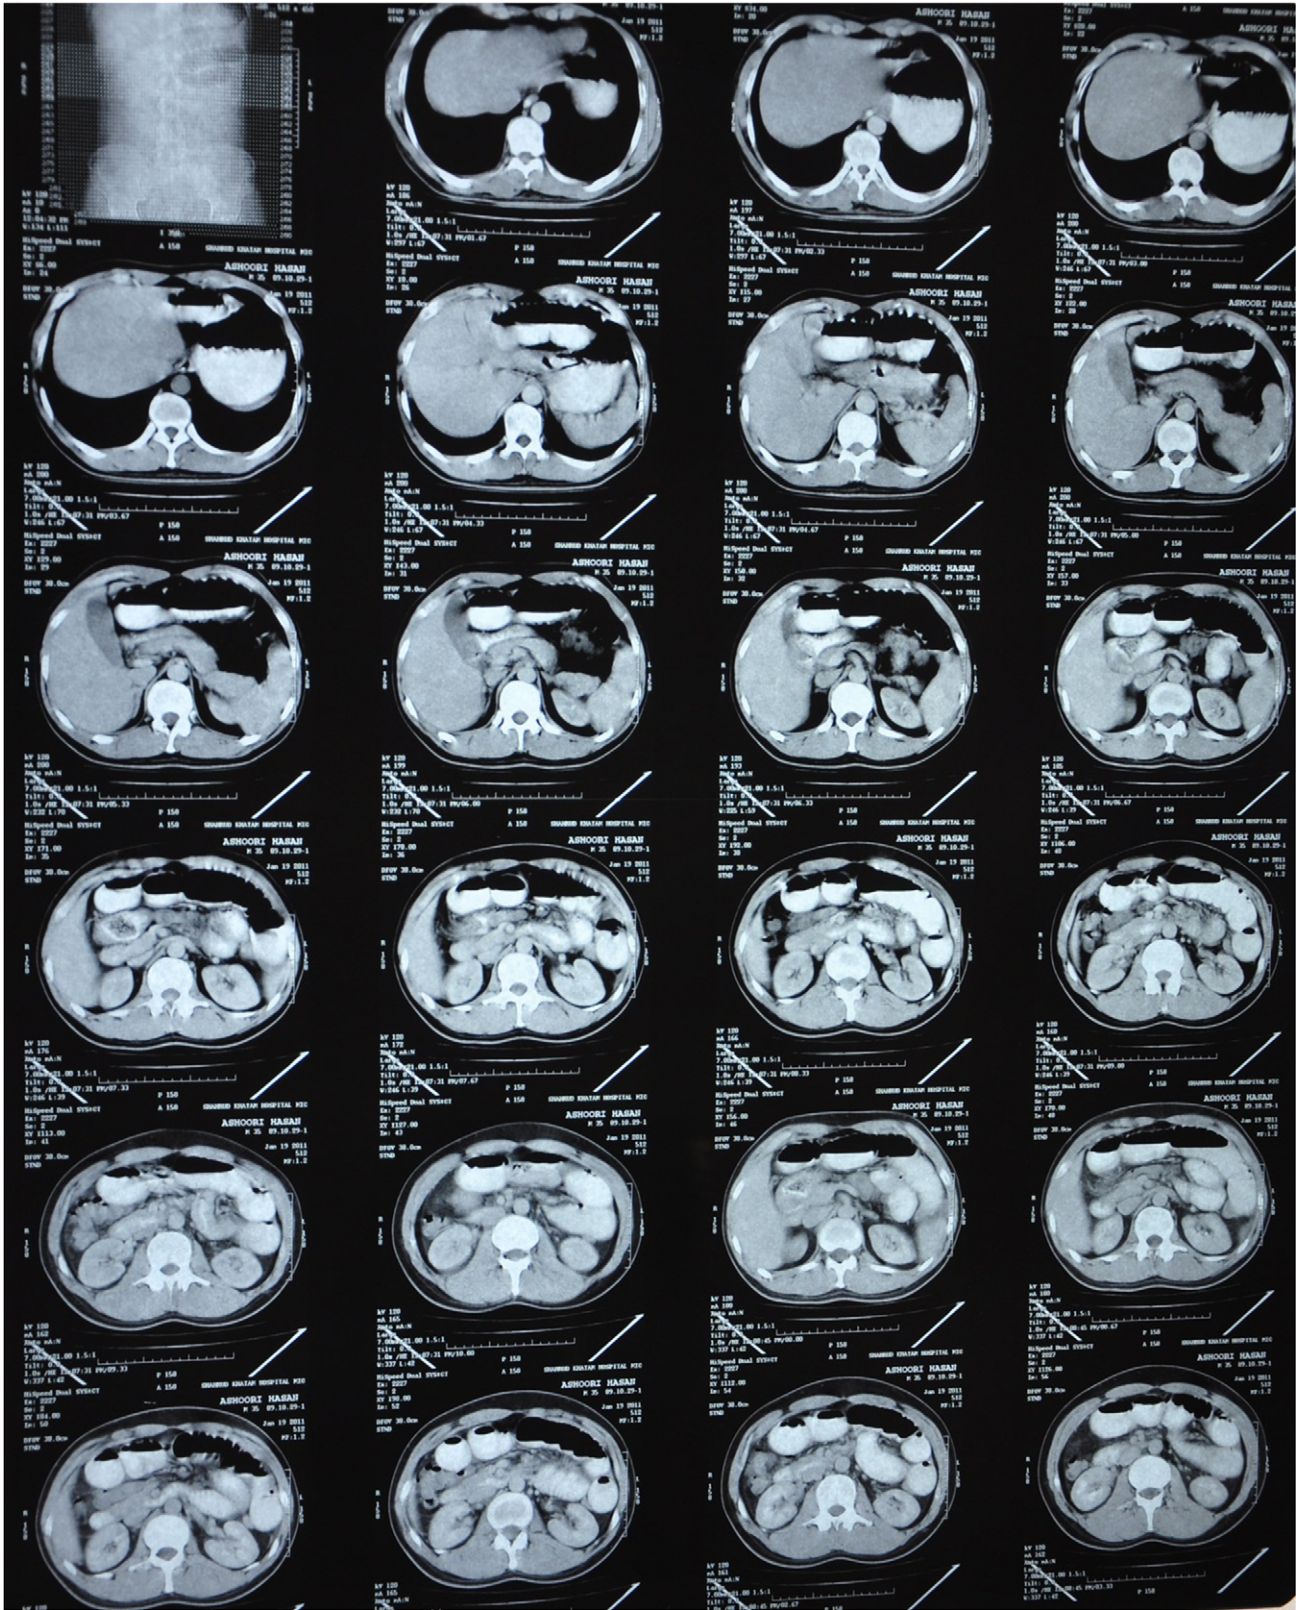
Contrast-enhanced CT scan of abdomen revealed small bowel dilation.
